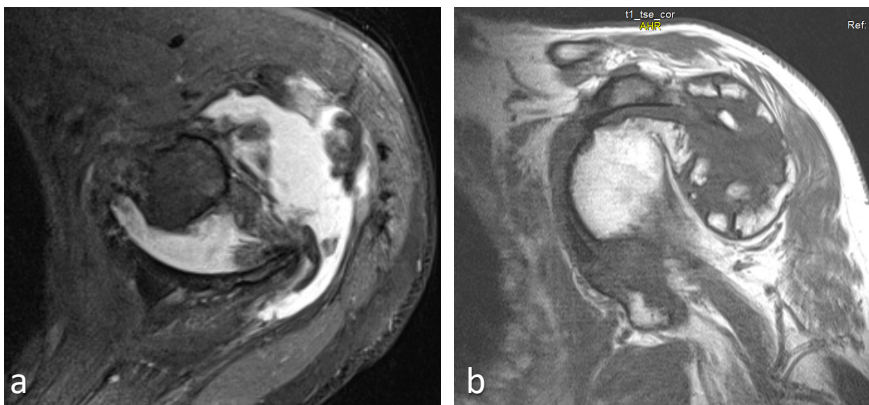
Left shoulder MRI, with axial PD sequences with fat saturation (a) and coronal T1 (b), which demonstrate an extensive joint effusion and the intra-articular location of multiple bone fragments.
